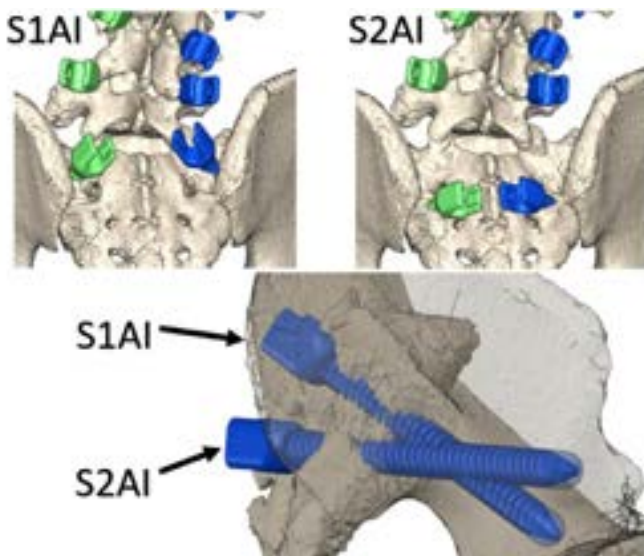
3D CT models of the S2AI and S1AI screw trajectories demonstrating entry point and trajectory as well as implant prominence
